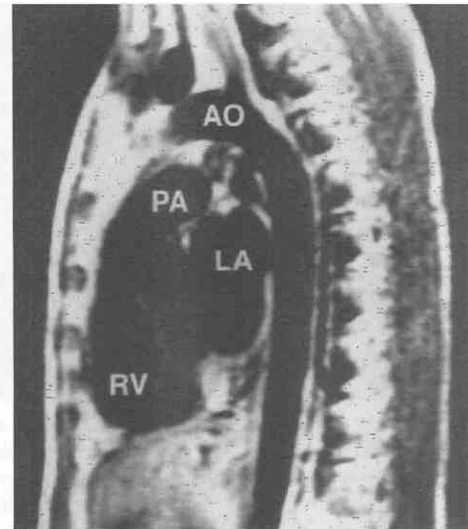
Sagittal MR image of the main pulmonary artery. AO, aorta; LA, left atrium; PA, main pulmonary artery; RV, right ventricle.
